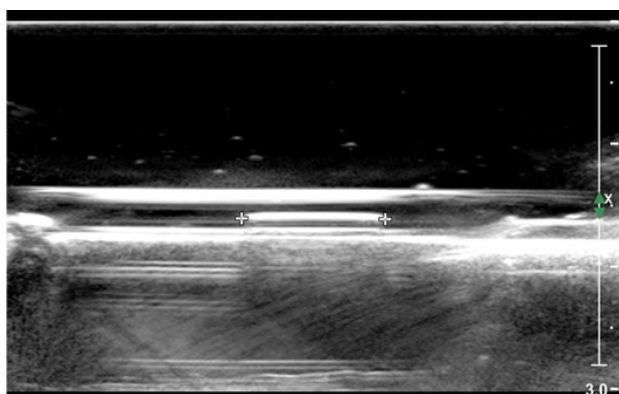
Ultrasonography shows the IV catheter fragment
